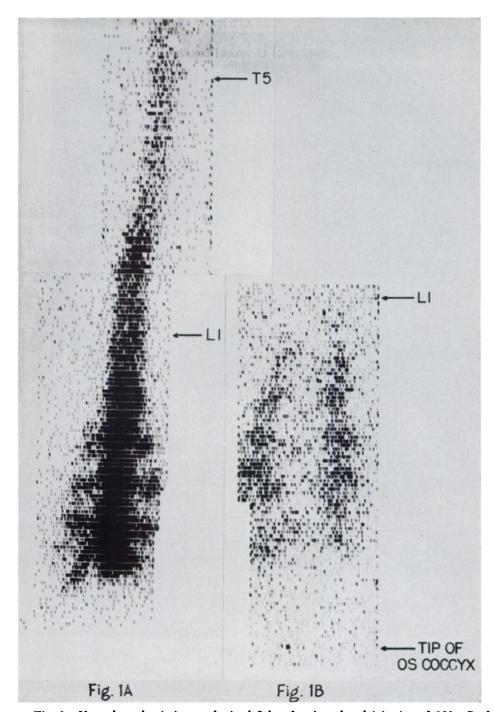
Normal myeloscintigram obtained 2 hr after intrathecal injection of 100 μ C of ^{131}I labeled human serum albumin. The scan shows a moderate scoliosis, but is otherwise normal. The radioiodinated human serum albumin is distributed throughout the spinal canal and appears in the nerve root sheaths.
